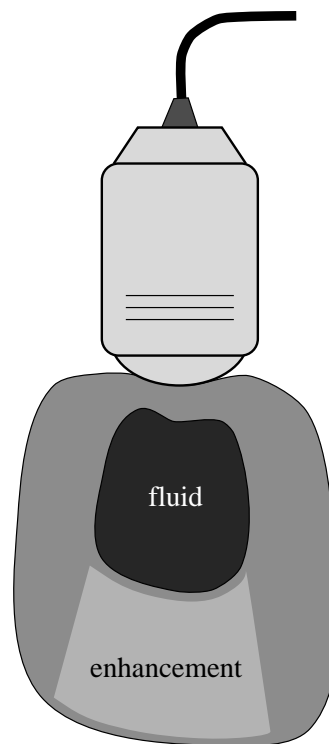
Enhancement artifact. When the ultrasound pulse passes through an anechoic region, such as a fluid filled cavity, little of the acoustic energy is absorbed. Since the time-gain amplification attempts to compensate for higher attenuation at greater depths, over-amplification occurs below the anechoic region.
